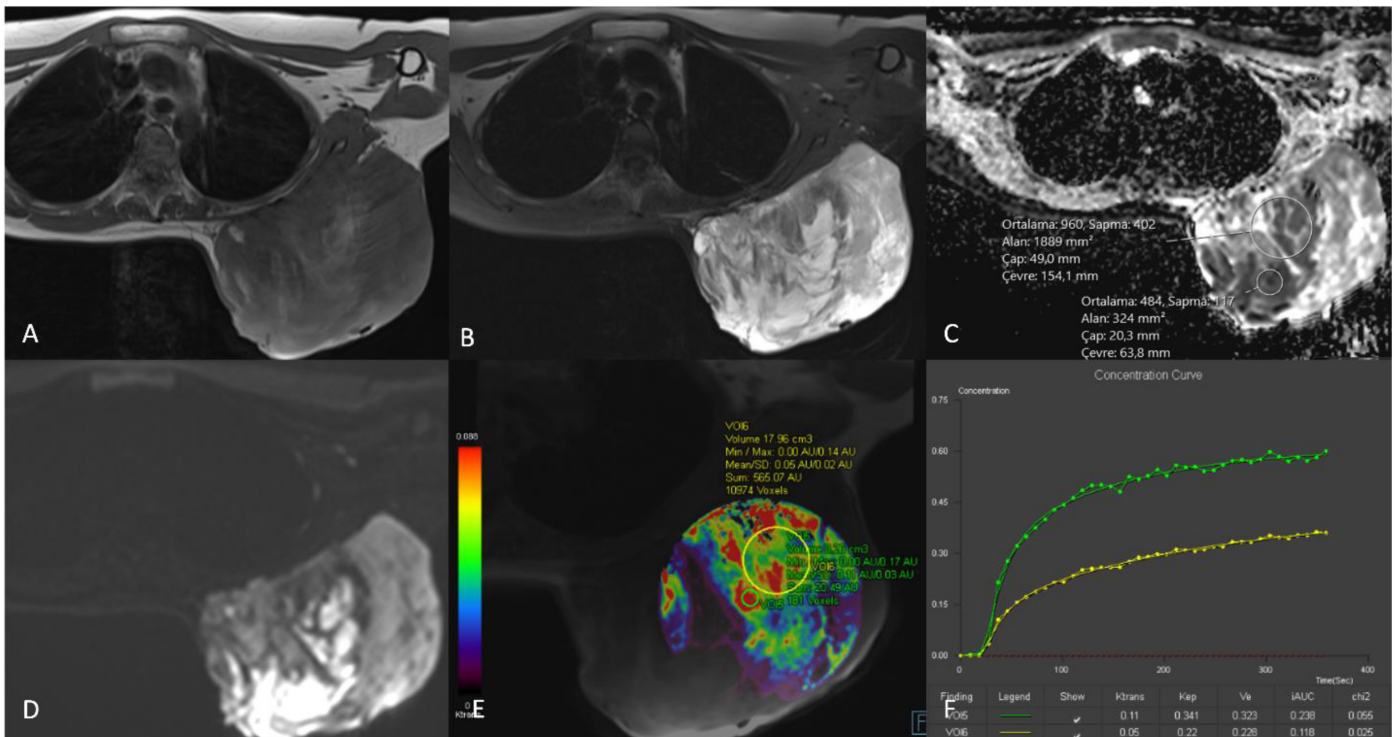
A 23-year-old female patient with synovial sarcoma of the back (grade 3). A: axial T1WI. B: axial FS T2WI. C and D: ADC map, DWI images (b800). E and F: Ktrans map and dynamic curves.
